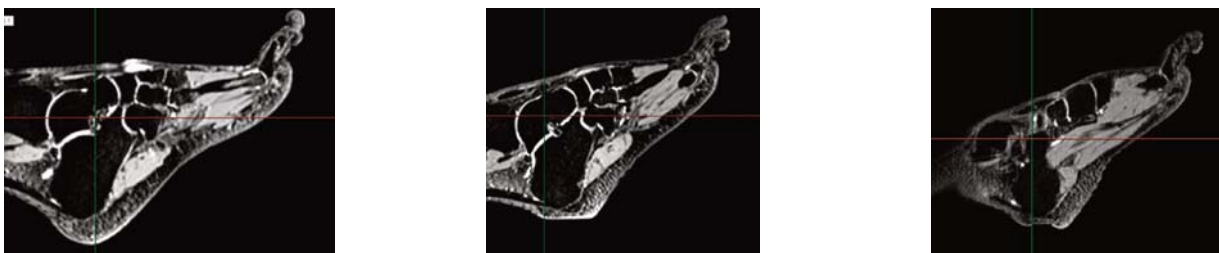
MR images related to the configurations for A unloaded, B loaded on hard surface, C loaded with an indenter.
